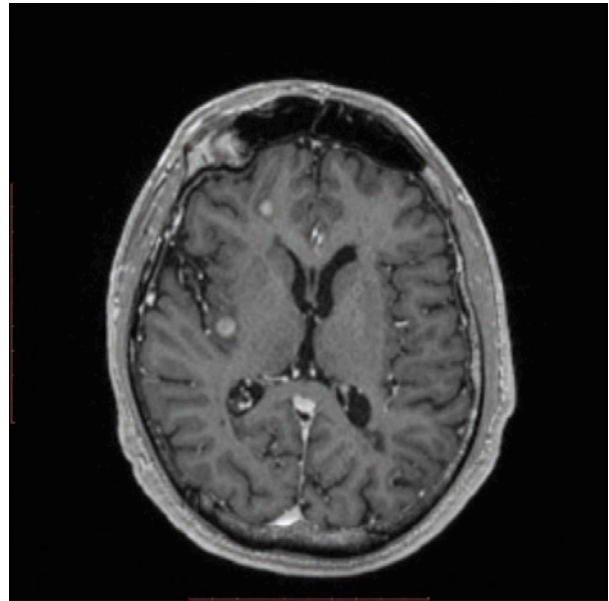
Multiple contrast-enhancing lesions-on-contrast enhanced T1 MRI, May 2017
